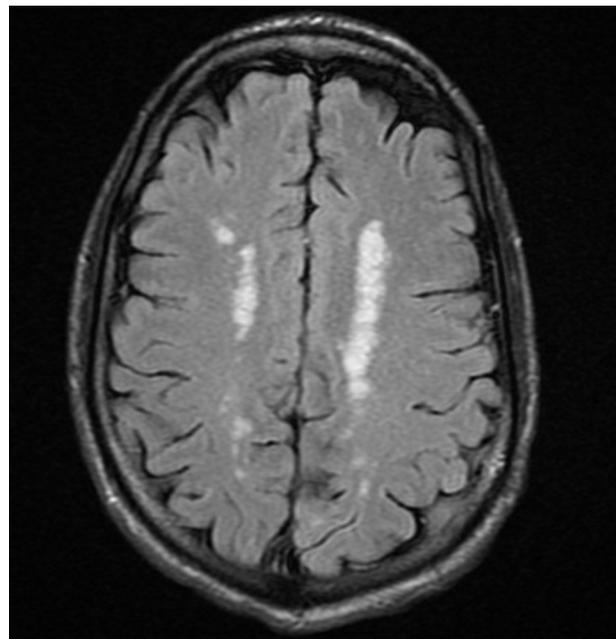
Brain MRI showing hyperintense lesions in the white matter during an attack of acute porphyria.
